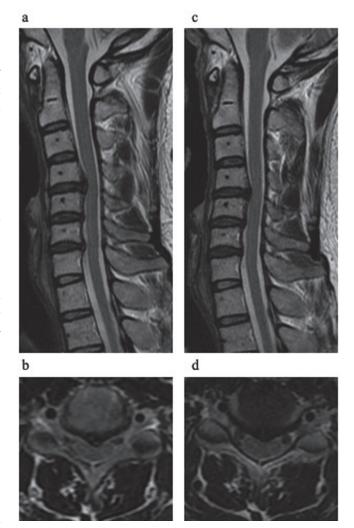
T2-weighted magnetic resonance imaging scans showing patient progress. (a) Image taken in the sagittal plane 5 years after initial onset (before AM); (b) image taken in the axial plane 5 years after initial onset (before AM) (CDH diameter at C4–5: 5.5 mm); (c) image taken in the sagittal plane 7 years after initial onset (2 years after AM); (d) image taken in the axial plane 7 years after initial onset (2 years after AM); (d) image taken in the axial plane 7 years after at C4–5: 4.2 mm).
